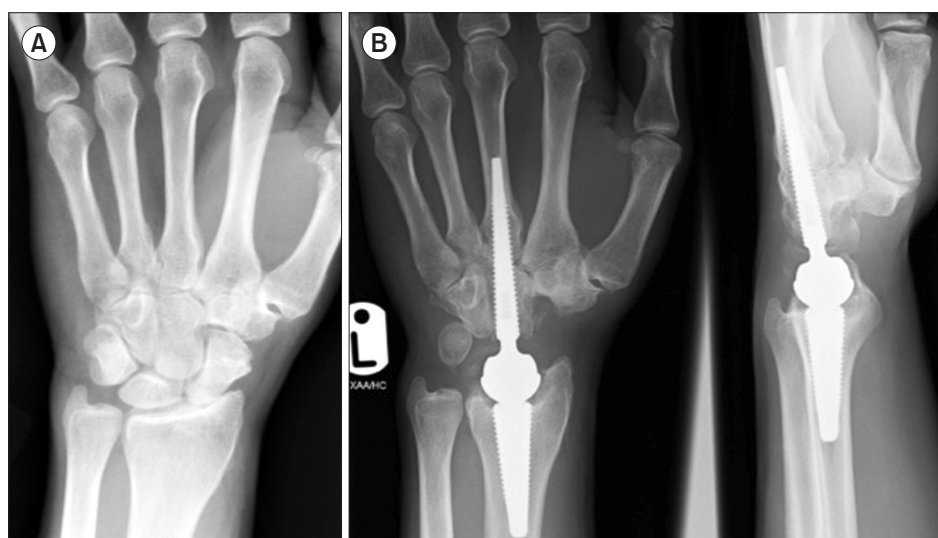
(A) Pre-operative AP radiograph of a wrist with Grade 4 SLAC, (B) Post-operative AP and lateral radiographs of a wrist with the implanted Motec arthroplasty.
